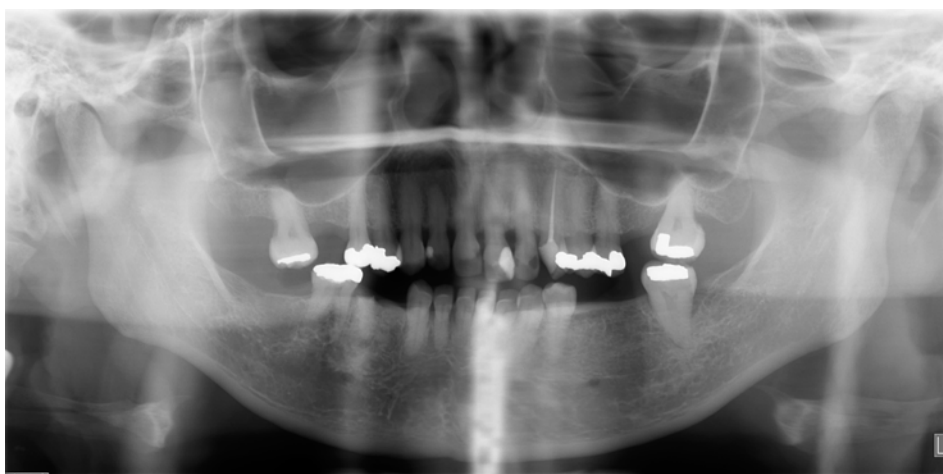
The inferior mandibular cortex on this panoramic radiograph represents the C1 stage of osteoporosis, showing an even and sharp endosteal margin of the cortex.
